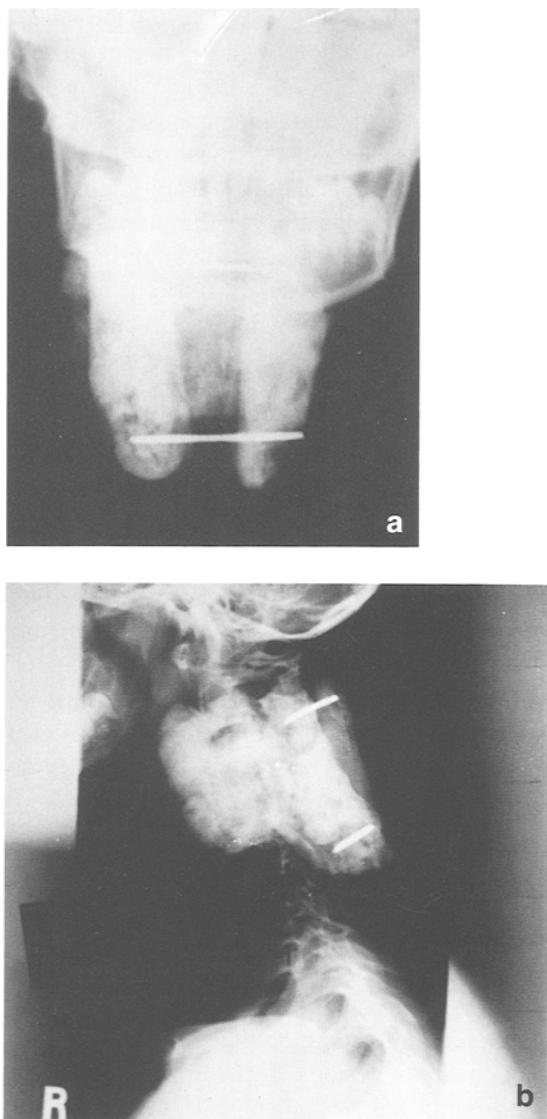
a, b. The antero-posterior (a) and lateral (b) cervical spine x-rays showed an extensive paraspinous growth of a cervical osteoblastic lesion, and the threaded pins placed through the spinous processes of the C2 and C5 vertebrae, for posterior spinal fusion (case 4)
